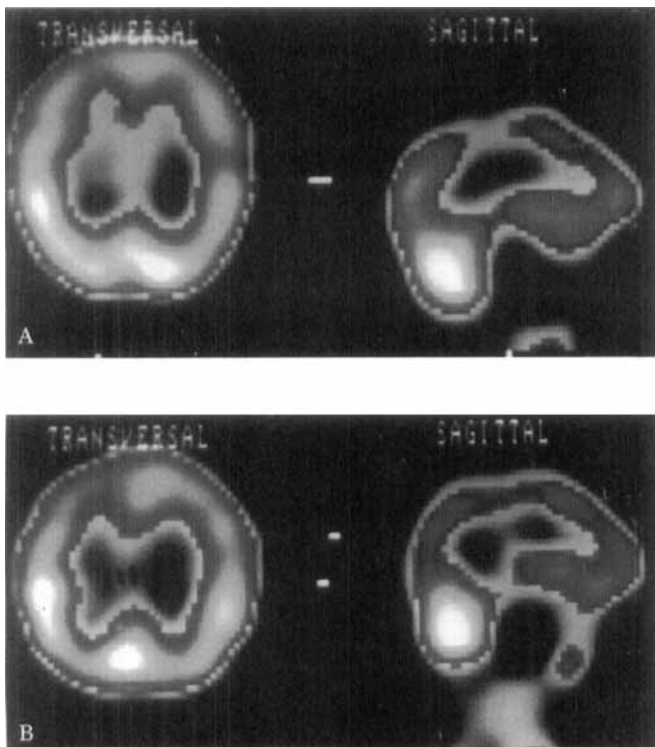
SPECT scans performed during (A) and after (B) the episode of transient memory loss. Transverse images are shown on the left side of each figure and sagittal images are shown on the right side of each figure. Hypoperfusion of the right temporal and parietal regions was detected during the attack. Cerebral perfusion appeared normal 1 week later.
